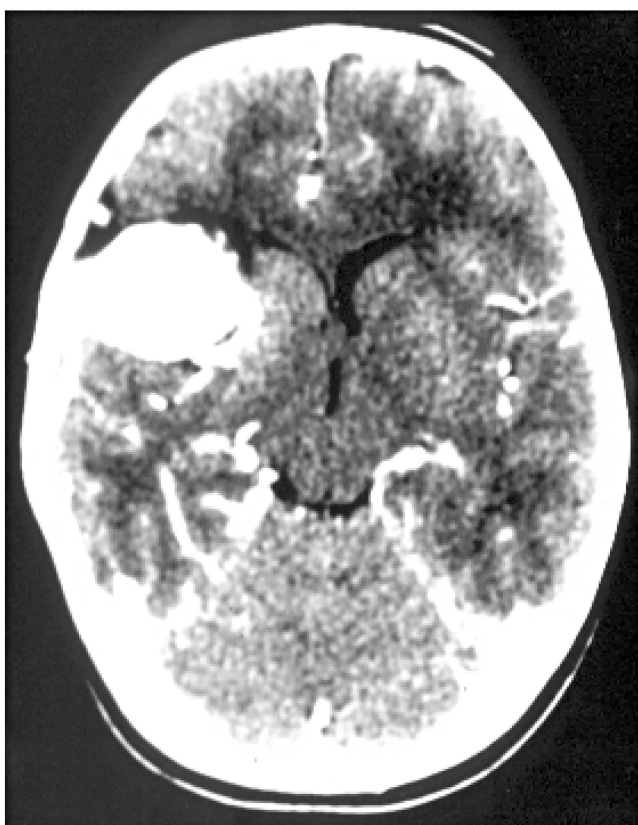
Postnatal post-contrast CT scan demonstrates an intense and homogeneous contrast-filling of a mass lesion located within the right Sylvian fissure similar in location and appearance to the prenatal ultrasound scan.
